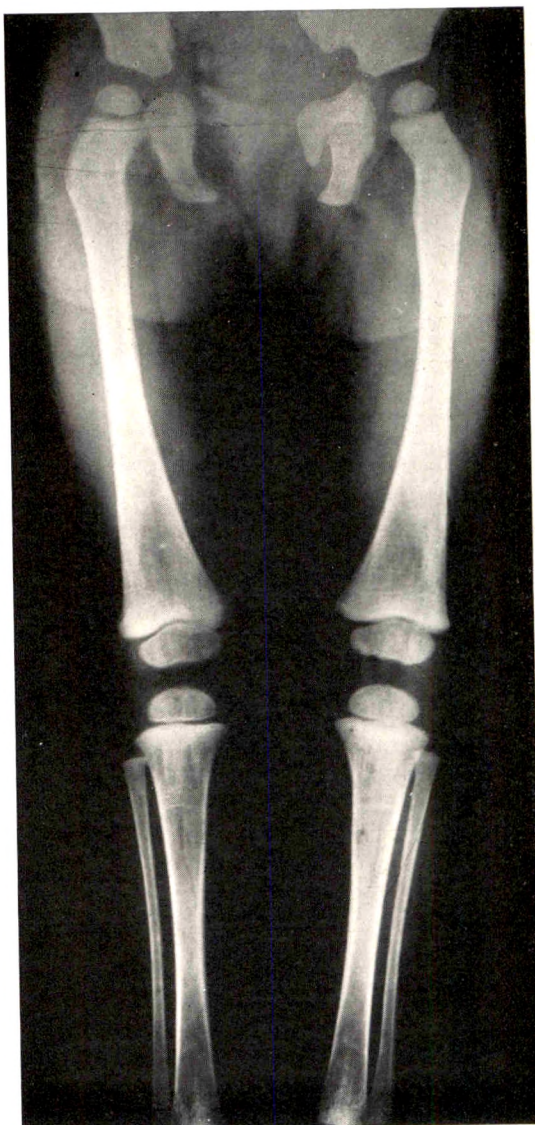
Case II. Note the slightly increased bone density. Less marked trabeculation. Increased transverse striation, following roentgen treatment.
